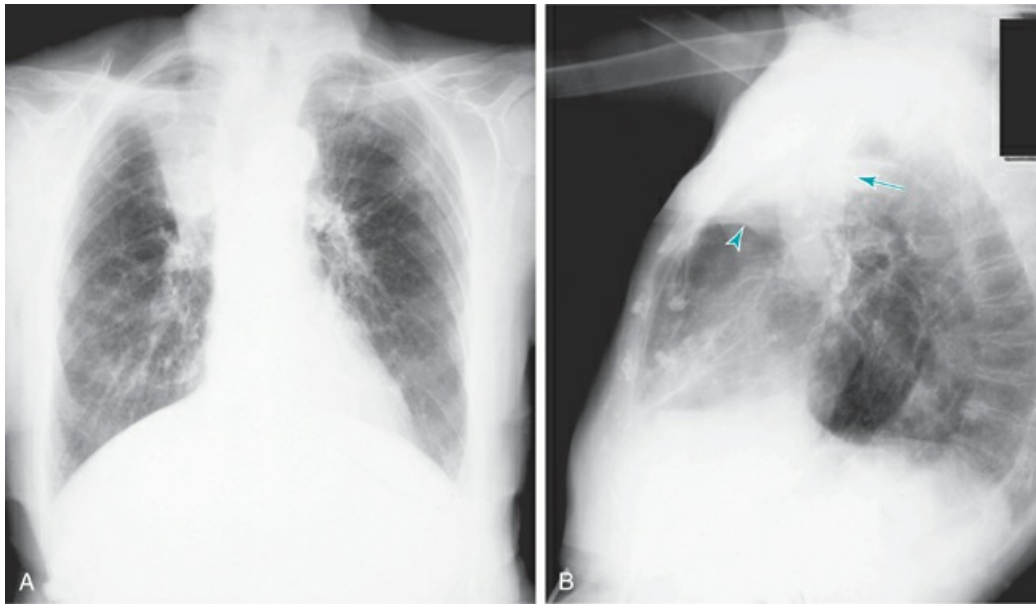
Posteroanterior (A) and lateral (B) chest radiographs demonstrating right upper lobe collapse. A, Displaced minor fissure outlines the airless (dense) right upper lobe. B, Right upper lobe is outlined by an elevated minor fissure (*arrowhead*) and an anteriorly displaced major fissure (*long arrow*).
